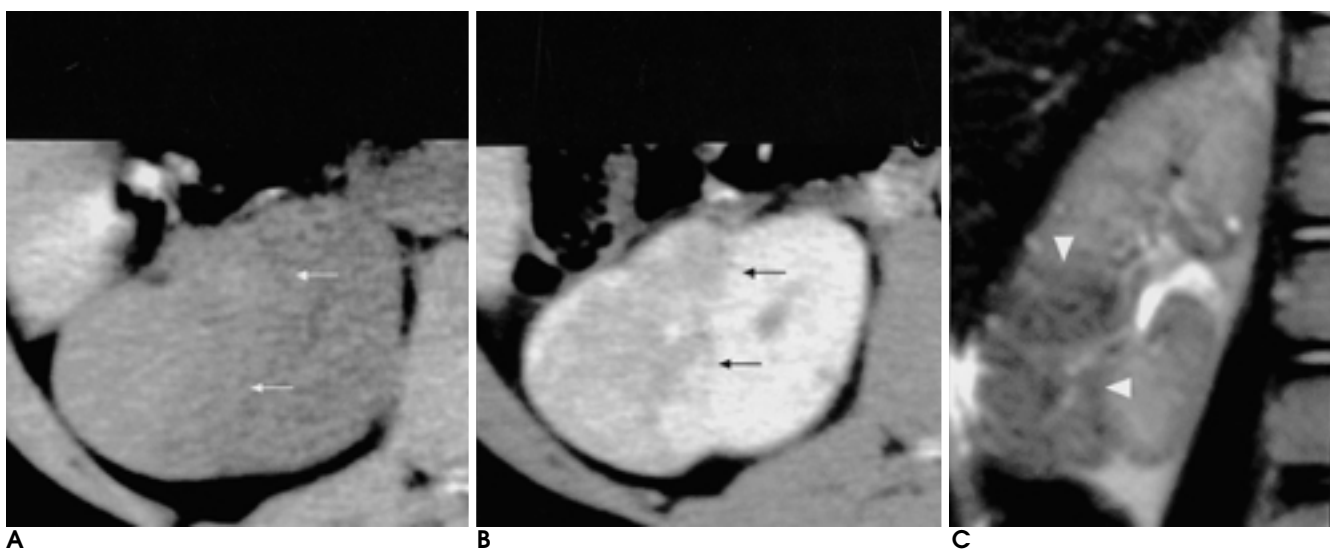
A 9-year-old man with muscle-predominant AML with lobulating contour. On non-enhanced CT scan (A), the mass lesion is slightly hyperdense than normal renal parenchyme. It is moderately enhanced on enhanced CT scan (B). Medial border of the mass is irregular (arrows). Coronal T2-weighted MR image (C) well shows lobulated contour (arrowheads) of this mass, which is hypointense than normal parenchyme.
